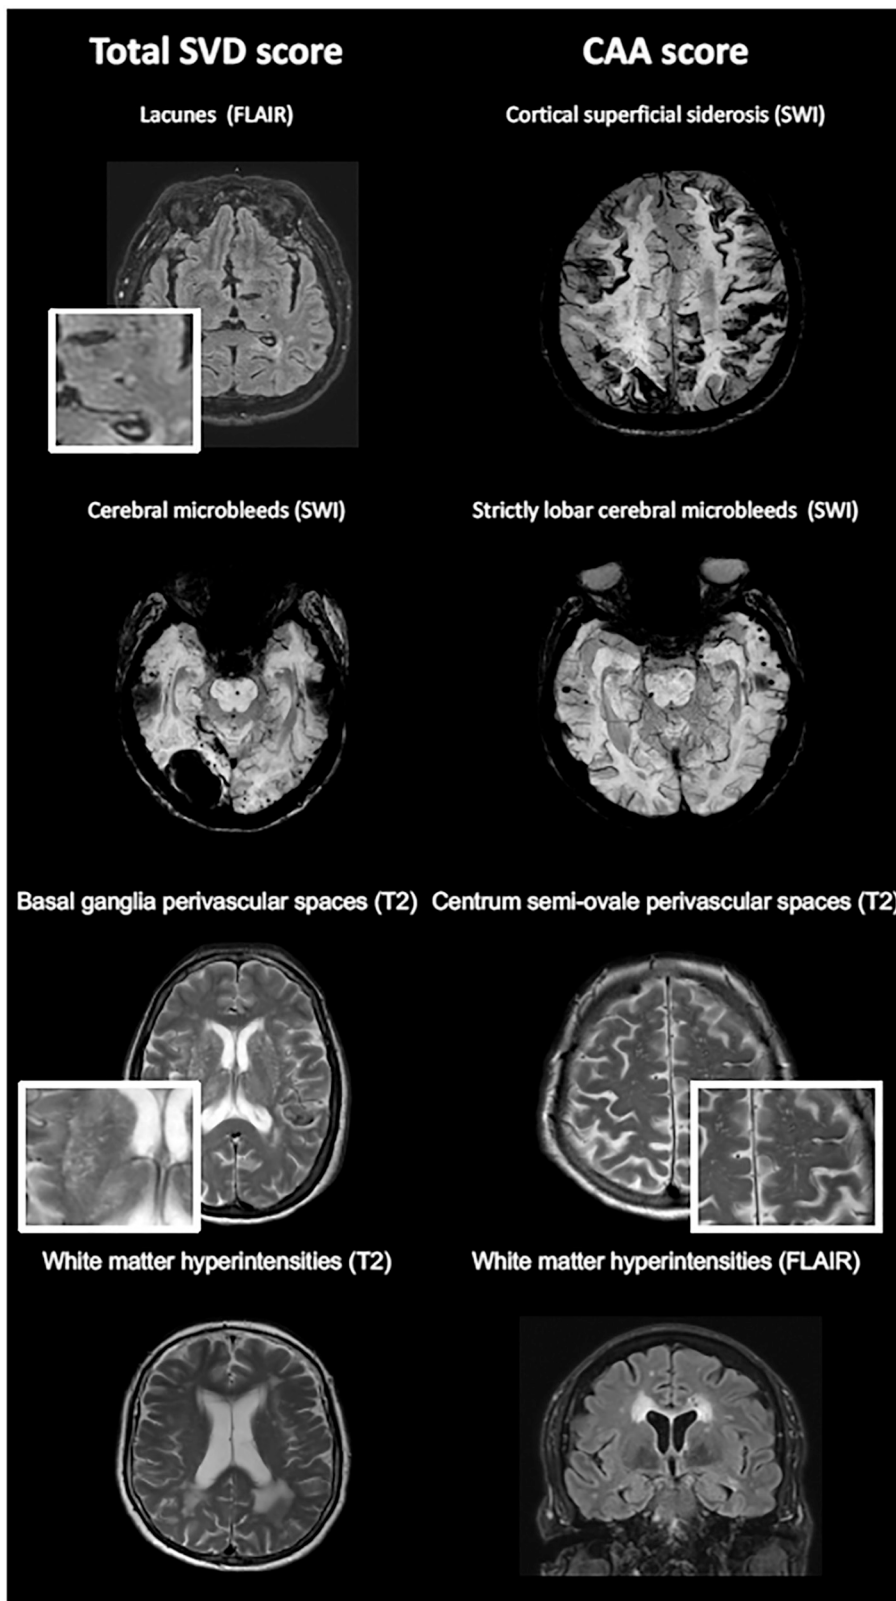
MRI examples of SVD markers included in Total SVD score and CAA score. SVD, small vessel disease; CAA, cerebral amyloid angiopathy; FLAIR, fluid-attenuated inversion recovery; SWI, susceptibility weighted imaging.
